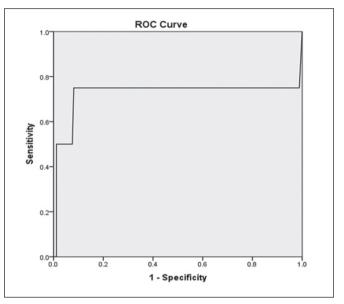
Receiver operating characteristic curves for GFAP to distinguishing between the presence and absence of intracranial lesions on CT scan. AUC 42.5% (73.5% - 11/5% CI: 95%).
